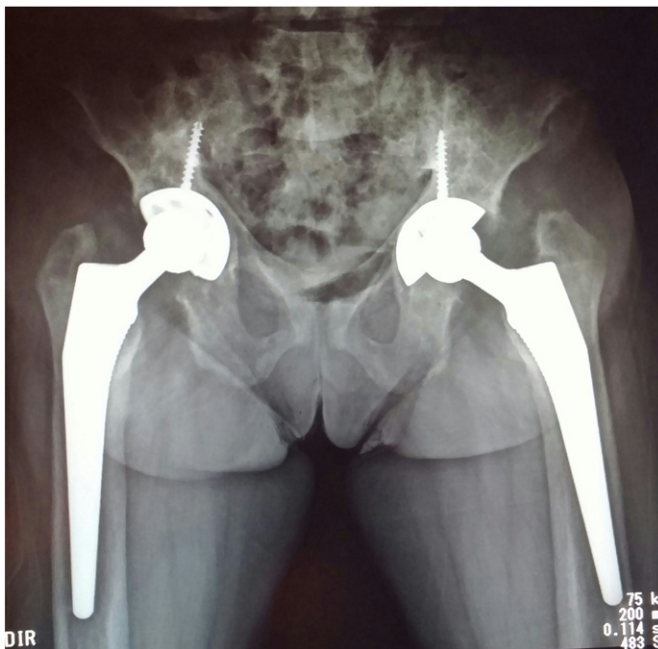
X-ray image showing the absence of osteolysis, good osseointegration of prosthetic components to the right and acetabular components to the left, with migration of the femoral component and increased left femoral varus.
